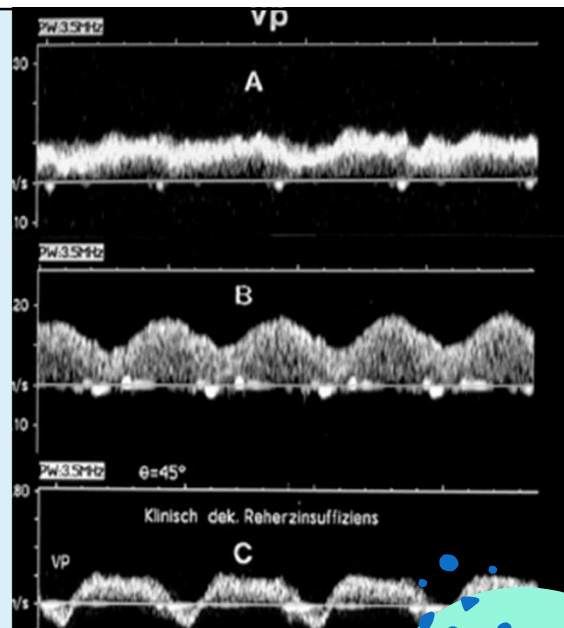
Spectral Doppler of main portal vein demonstrating normal (a), pulsatile (b) and biphasic flow (c).
